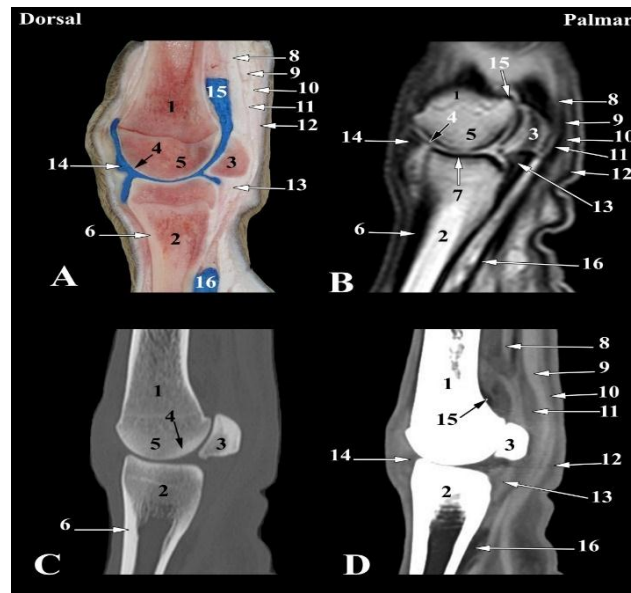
Sagittal images of right fore fetlock joint of camel (level 6 as indicated in Fig. 1). A- Sagittal anatomical section; B- Magnetic resonance image; C- Bone window computed tomography image; D- Soft tissue window computed tomography image: 1- Metacarpus; 2- First phalanx; 3- Proximal sesamoid bone; 4- Articular cartilage; 5- Cancellous bone; 6- Cortical bone; 7- Subchondral bone; 8- Suspensory ligament; 9- Deep digital flexor tendon; 10- superficial digital flexor tendon; 11- Manica flexoria; 12- Annular ligament; 13- Straight sesamoidean ligament; 14- Dorsal synovial pouch of fetlock joint; 15- Palmar synovial pouch of fetlock joint; 16- Palmar synovial pouch of pastern joint.
